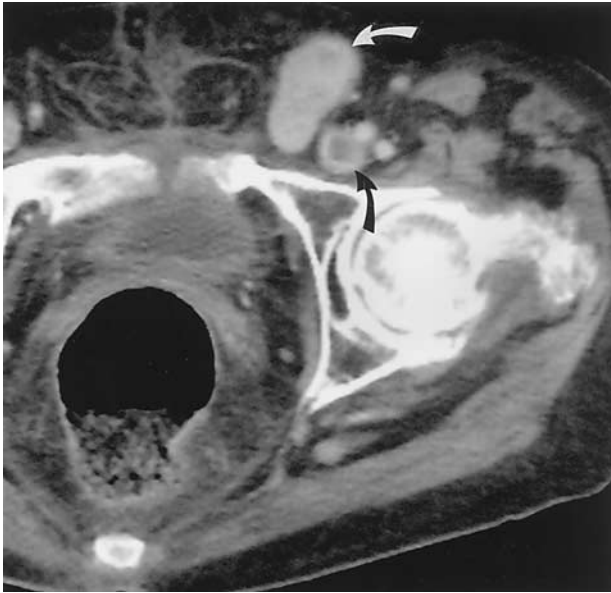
Pretreatment pelvis CT scan after intravenous contrast administration shows enhancing superficial mass (white arrow). Incidental note is made of the deep venous thrombosis in the common femoral vein (black arrow).
